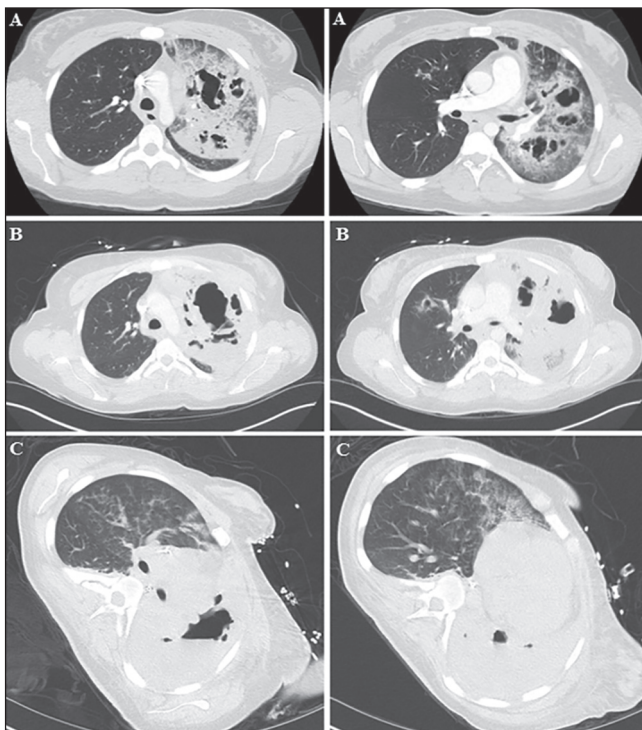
Computed tomography chest showing necrotic cavitary pneumonia on day 1 (a) with progression to frank necrosis and cavitation on day 6 (b) and day 22 (c)
